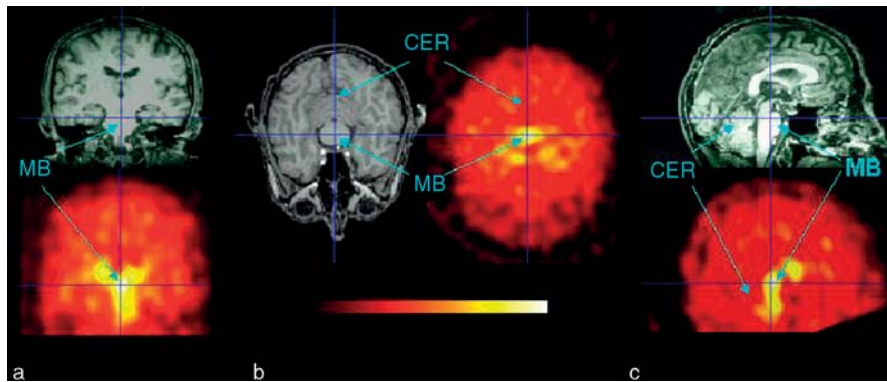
Multiple projections of ^{123}I ADAM SPECT and corresponding MRIs showing areas of substantial serotonin transporter binding in the midbrain with relatively little uptake in the cortex and cerebellum: (a) coronal; (b) transaxial; and (c) sagittal. CER, cerebellum; MB, midbrain.
